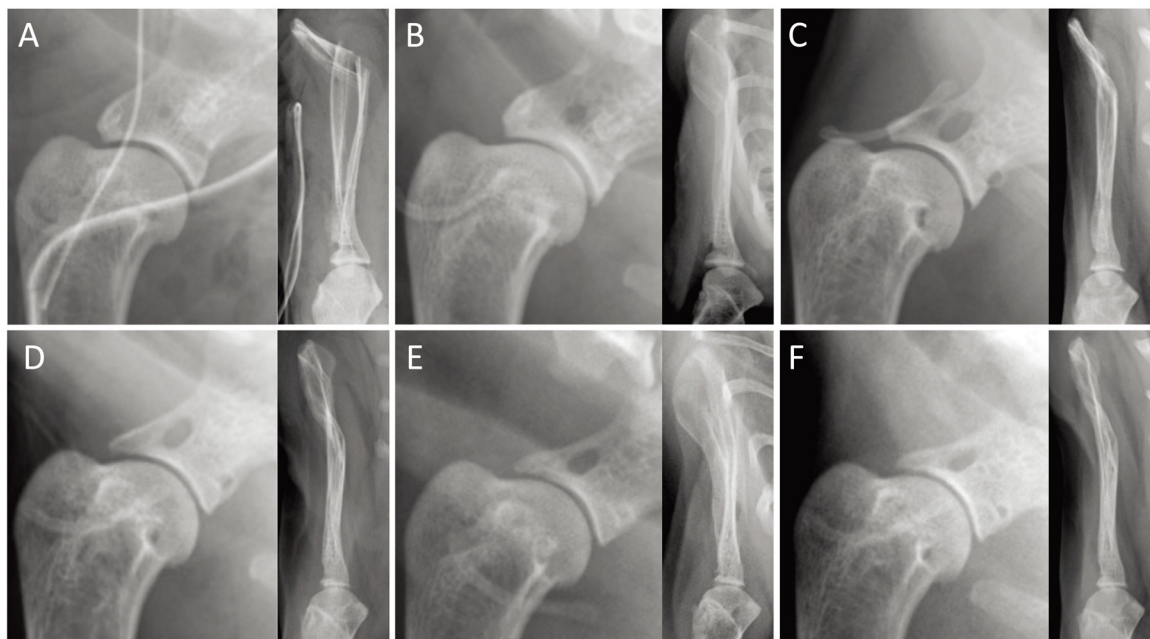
Postoperative radiographs of the shoulder joint and scapula at (A) 1 month; (B) 3 months; (C) 6 months; (D) 12 months; (E) 24 months; (F) The shoulder dislocation and bone fracture are not visible on radiograph at any follow-up time points.
